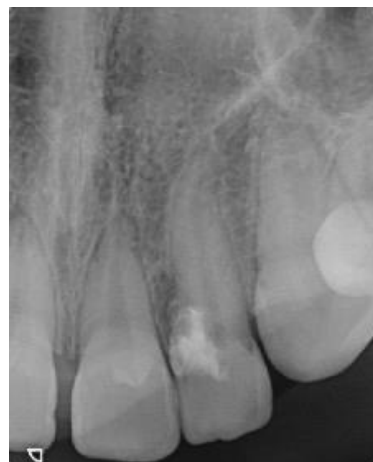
The 2-year follow-up periapical radiograph of maxillary left lateral incisor.
